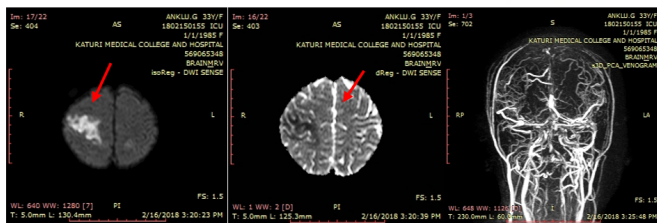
A & B - DWI and ADC map showing area of hyperintensity on DWI in right parietal lobe (arrow) with hypointense signal on ADC (arrow) indicating diffusion restriction, suggestive of infarct. C - MR Venogram showing absent flow in superior sagittal sinus and right transverse sinus, suggestive of thrombosis.
